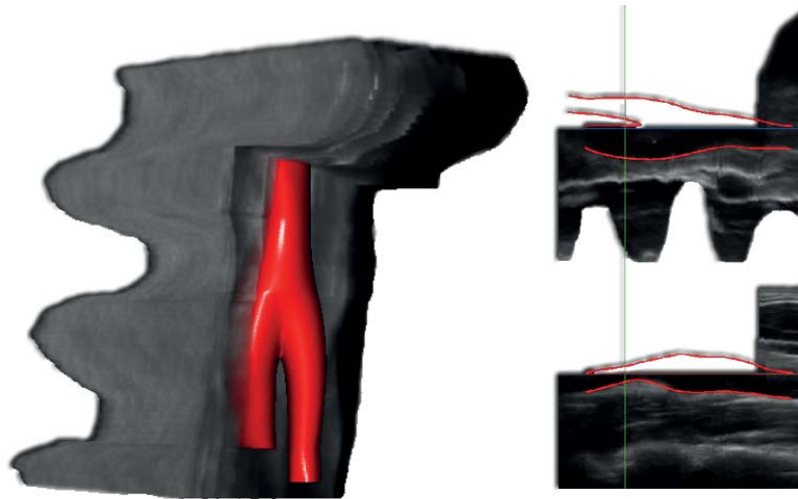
3D-reconstruction (left) and two longitudinal cuts (right) through a freehand 3D-ultrasound scan with periodical lateral displacement during movement along the artery. The segmentation of the Lumen boundary shows the bifurcation from the common to the internal and external Carotid artery. Images were acquired with a Curefab CS 3D ultrasound system.
